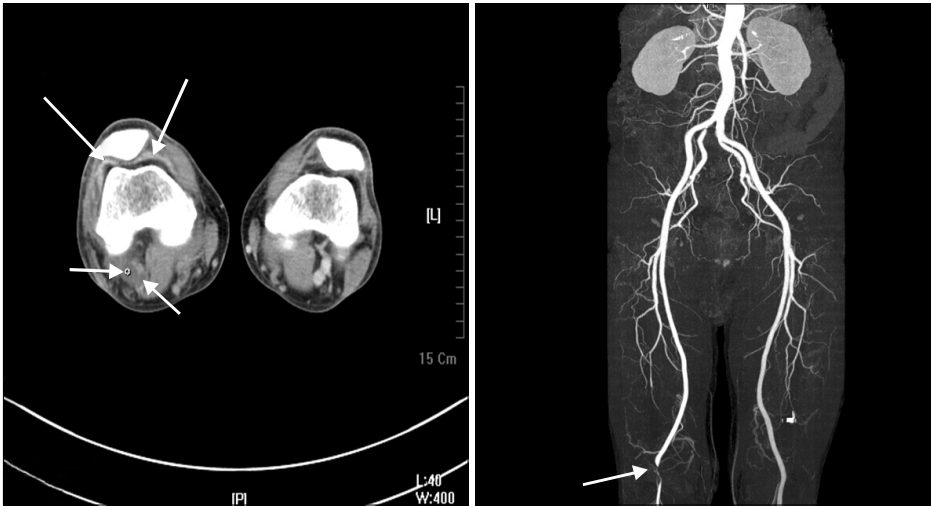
CT angiography shows that a multi-loculated cystic mass nearly obstructing the popliteal artery and cysts in the synovial area (arrows).
